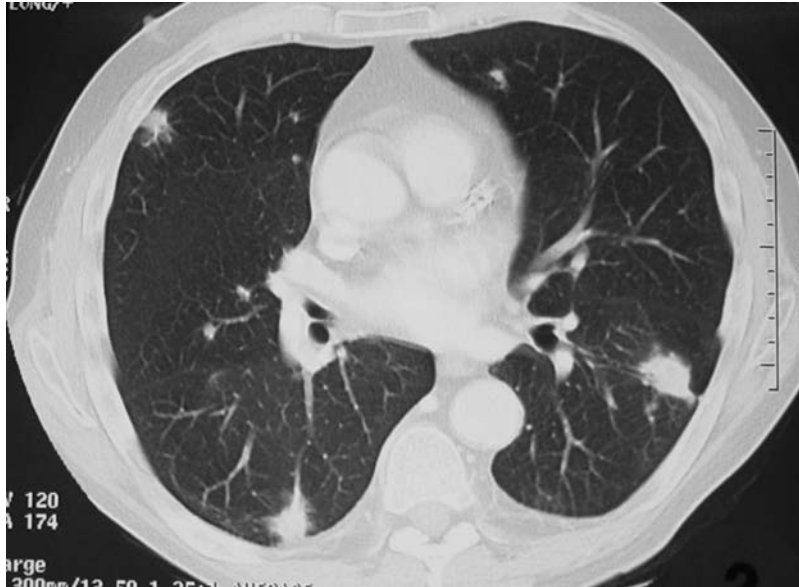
Thoracic CT scan shows multiple dense nodules in the pulmonary fields.
